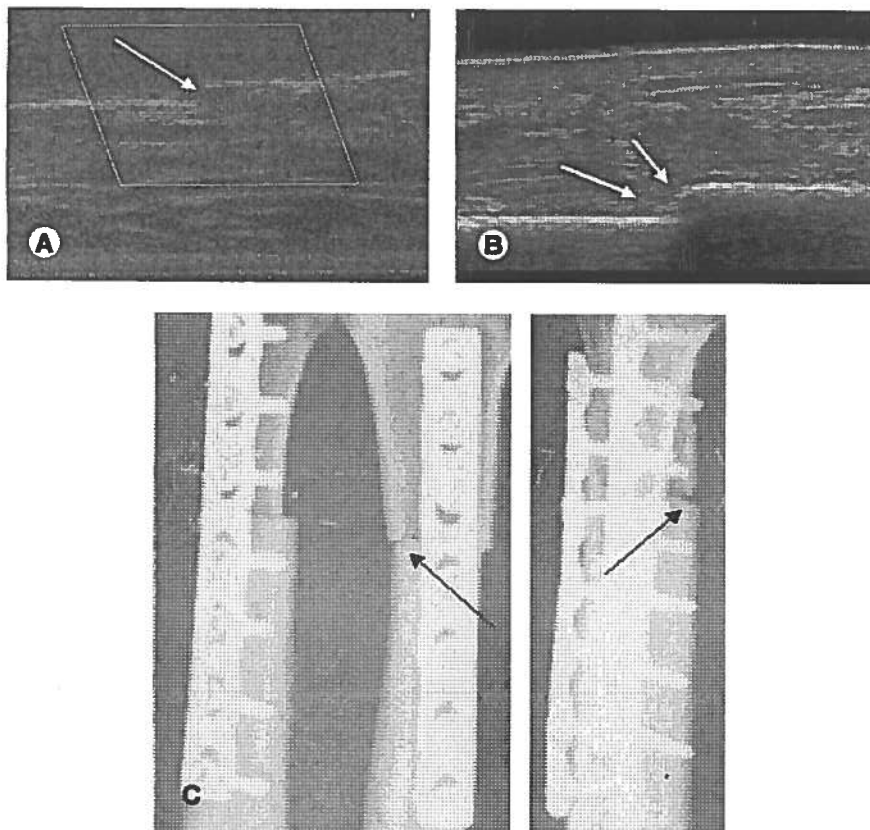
(A) Replant patient. Color Doppler ultrasound performed at week 6: no vessels. (B) Replant patient ultrasound B-mode: soft callus (arrows) was delineated at week 6. (C) Radiographs in anteroposterior and lateral projection show no calcifications at the osteotomy site (arrow).
